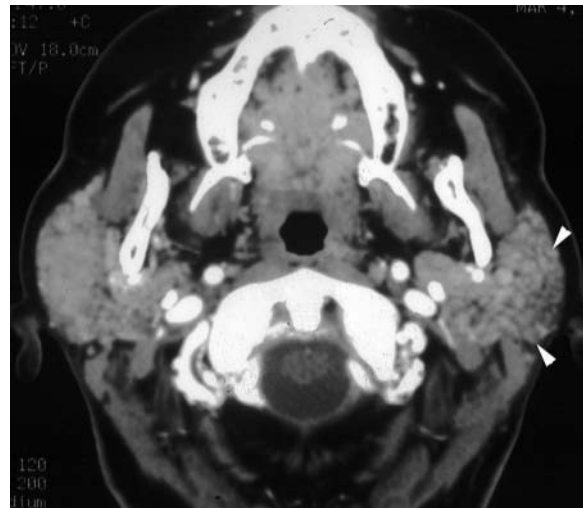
Sjögren's disease, CT. Axial CT after intravenous contrast shows a nodular or granular appearance throughout both parotid glands. Note the multiple small nodular densities (*arrowheads*)
